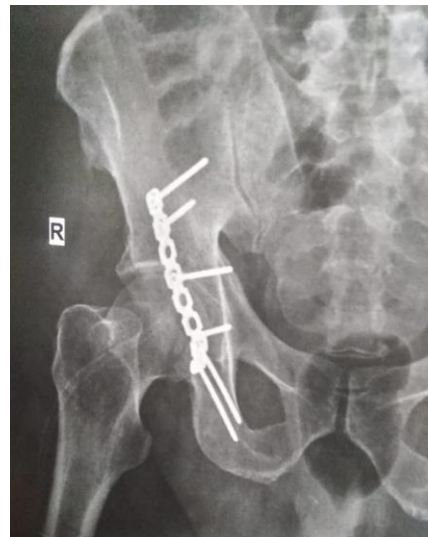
Plain X-ray of hip AP view shows post-operative fixation of fracture fracture by 2 interfragmentary screws and 3.5 mm reconstruction plate and 4 screws.
